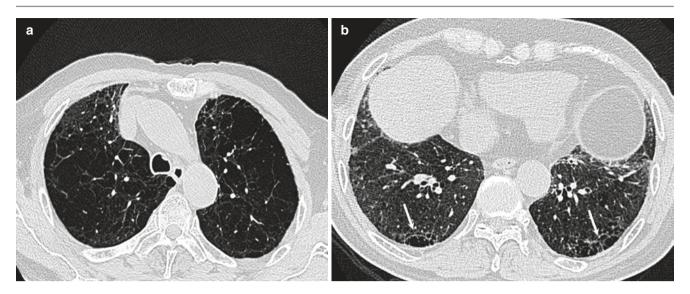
Presumed CPFE syndrome in a heavy smoker with severe pulmonary artery hypertension. (a) Axial CT image of the upper lung shows predominantly paraseptal emphysema. (b) Axial image of lower lungs shows mild fibrosis with TWLCs (white arrows)
